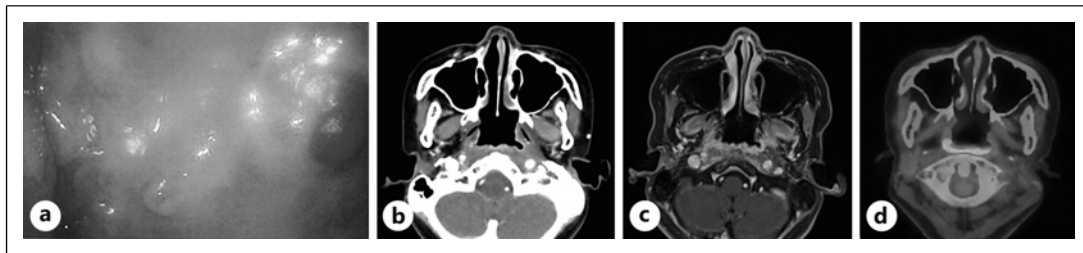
a Initial nasal endoscopy findings – Coarse mucosal irregularities observed throughout the nasopharynx. b Initial CT imaging findings – No tumor lesions detected in the nasopharynx. Absence of apparent cervical lymph node metastasis. c MRI findings [T1 contrast] – no evident neoplastic lesions, consistent with cervical contrast CT findings. d PET/CT findings – localized abnormal SUV max 15.6 accumulation in the nasopharynx. No indications of distant metastasis.
